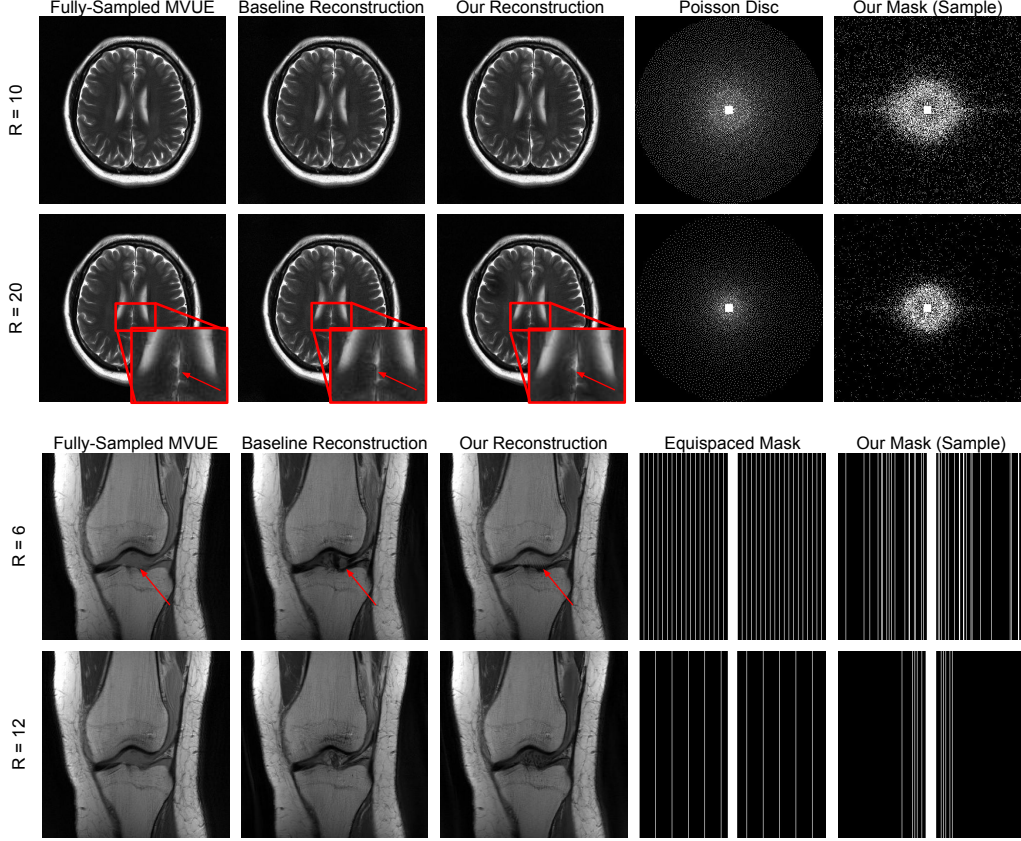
Reconstructions using baseline masks vs masks learned with our method. We perform posterior sampling using a diffusion model to reconstruct MRI scans using varying anatomies, pattern types, and acceleration factors (R). Artifacts in the reconstructions are highlighted with red arrows and insets (zoom may be needed). Masks learned with our method produce reconstructions with fewer artifacts.
